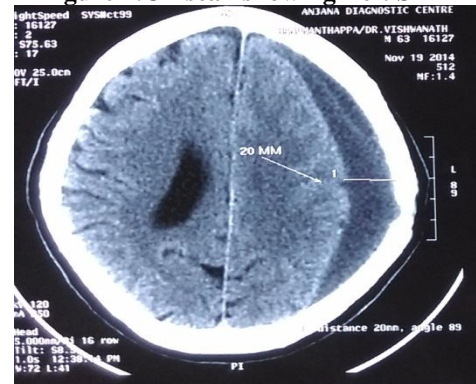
CT scan showing bilateral SDH
